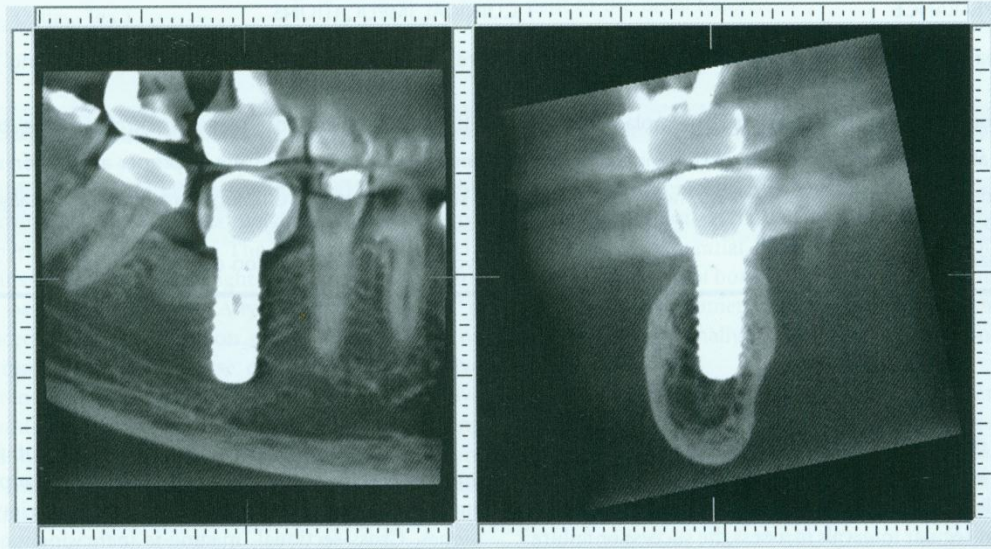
Reformatted cone-beam CT images of a symptomatic patient reveal embarrassment and compression of the mandibular canal by the implant.
